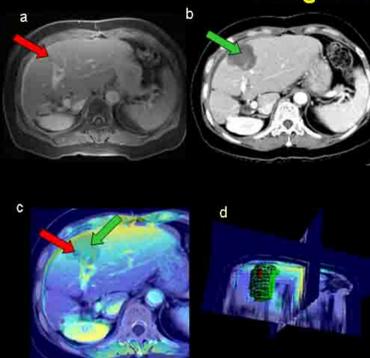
Pre- and post-treatment fusion images of a solitary hepatocellular carcinoma using the least squares method. This lesion was invisible on CT pre-RFA. The MRI was used to guide needle placement. (a) MR of tumor (arrow) before RFA. The CT (b) of RFA zone (arrow) after treatment. CT (c) to MR fusion demonstrates the ablation margins; notice that the tumor (yellow arrow) is within the kill zone (orange arrow). Three-dimensional rendering (d) of ablation zone (green) encompassing the tumor (red). This lesion was invisible on CT pre-RFA. The MRI was used to guide needle placement.
